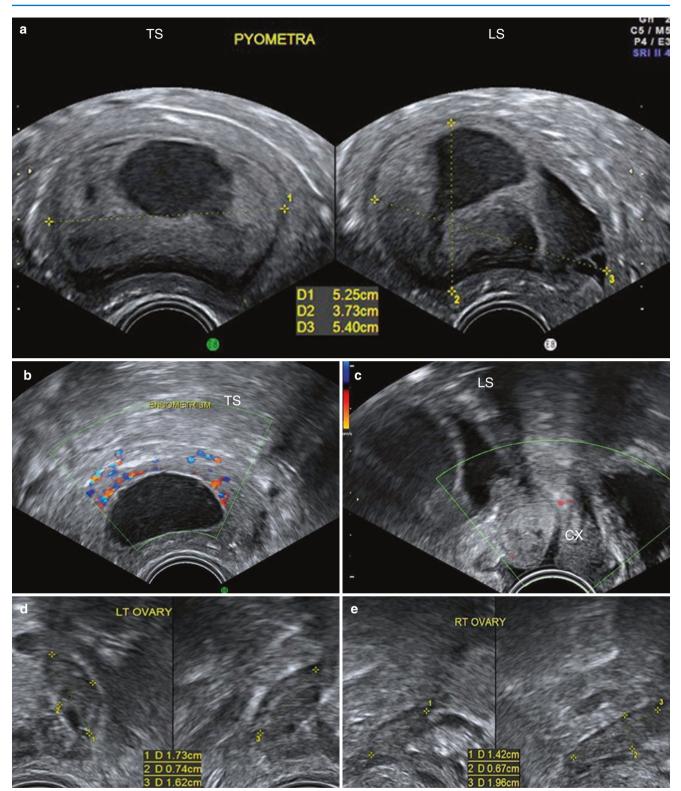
A 65-year-old patient who presented with a 10-day history of foul-smelling discharge. (a) Endometrial cavity is seen filled with turbid contents showing mixed echoes, suggestive of pus (Vol, 55 cc). (b) On Doppler, the subendometrial area shows moderate vascularity (which is not a normal finding in postmenopausal women). (c) The cervix in this patient was examined to rule out any local cause for the pyometra, like a cervical malignancy. In this patient, no abnormality was noted. (d, e) Both the adnexa appeared normal with bilateral atrophic ovaries. *HPE:* scanty endometrium with no malignancy noted in the endometrial and the endocervical curettings
